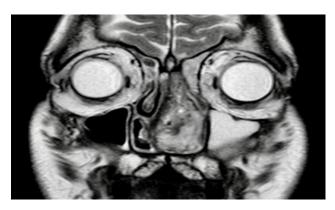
Coronal section of T2 -weighted MRI showing a heterogeneous and well-circumscribed mass lesion in left nasal cavity, with no orbital and intracranial extension.
